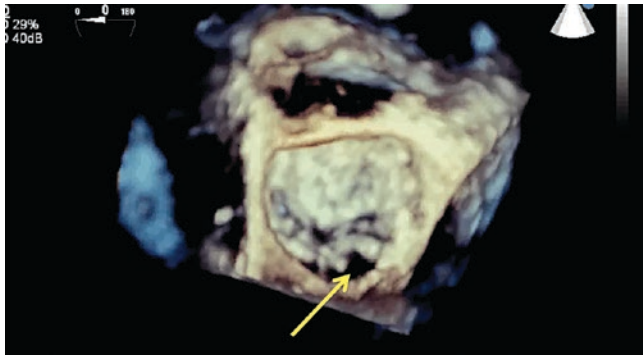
When utilizing 3D echocardiography, the echocardiographer has to be able to differentiate echocardiographic drop out (yellow arrow) from true defects
